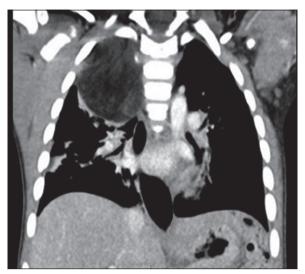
Chest Computed Tomography. A septated lesion of adipose tissue is observed in the right mediastinum of approximately 5 cm, with a density of less than 0 Hounsfield Units, reported as mediastinal lipoblastoma.
